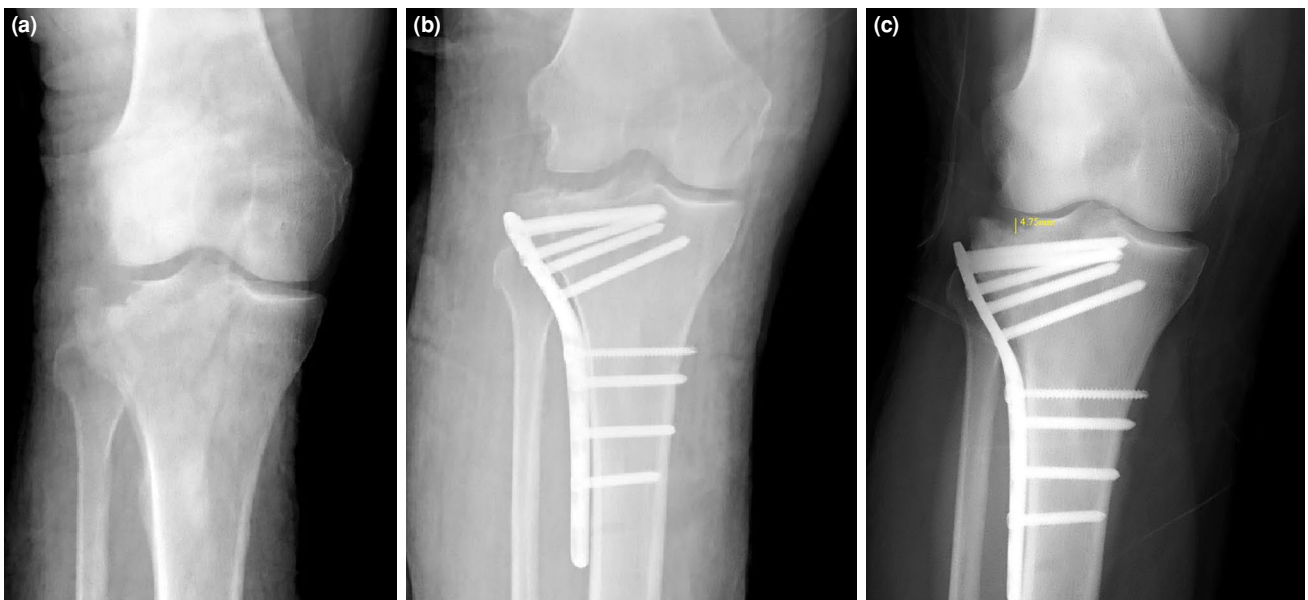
Radiographic images of a patient with recurrent joint depression during follow-up: (a) preoperative tibial plateau fracture with joint depression, (b) postoperative radiograph showing achieved reduction, (c) radiograph in the second postoperative year showing recurrent joint depression.
